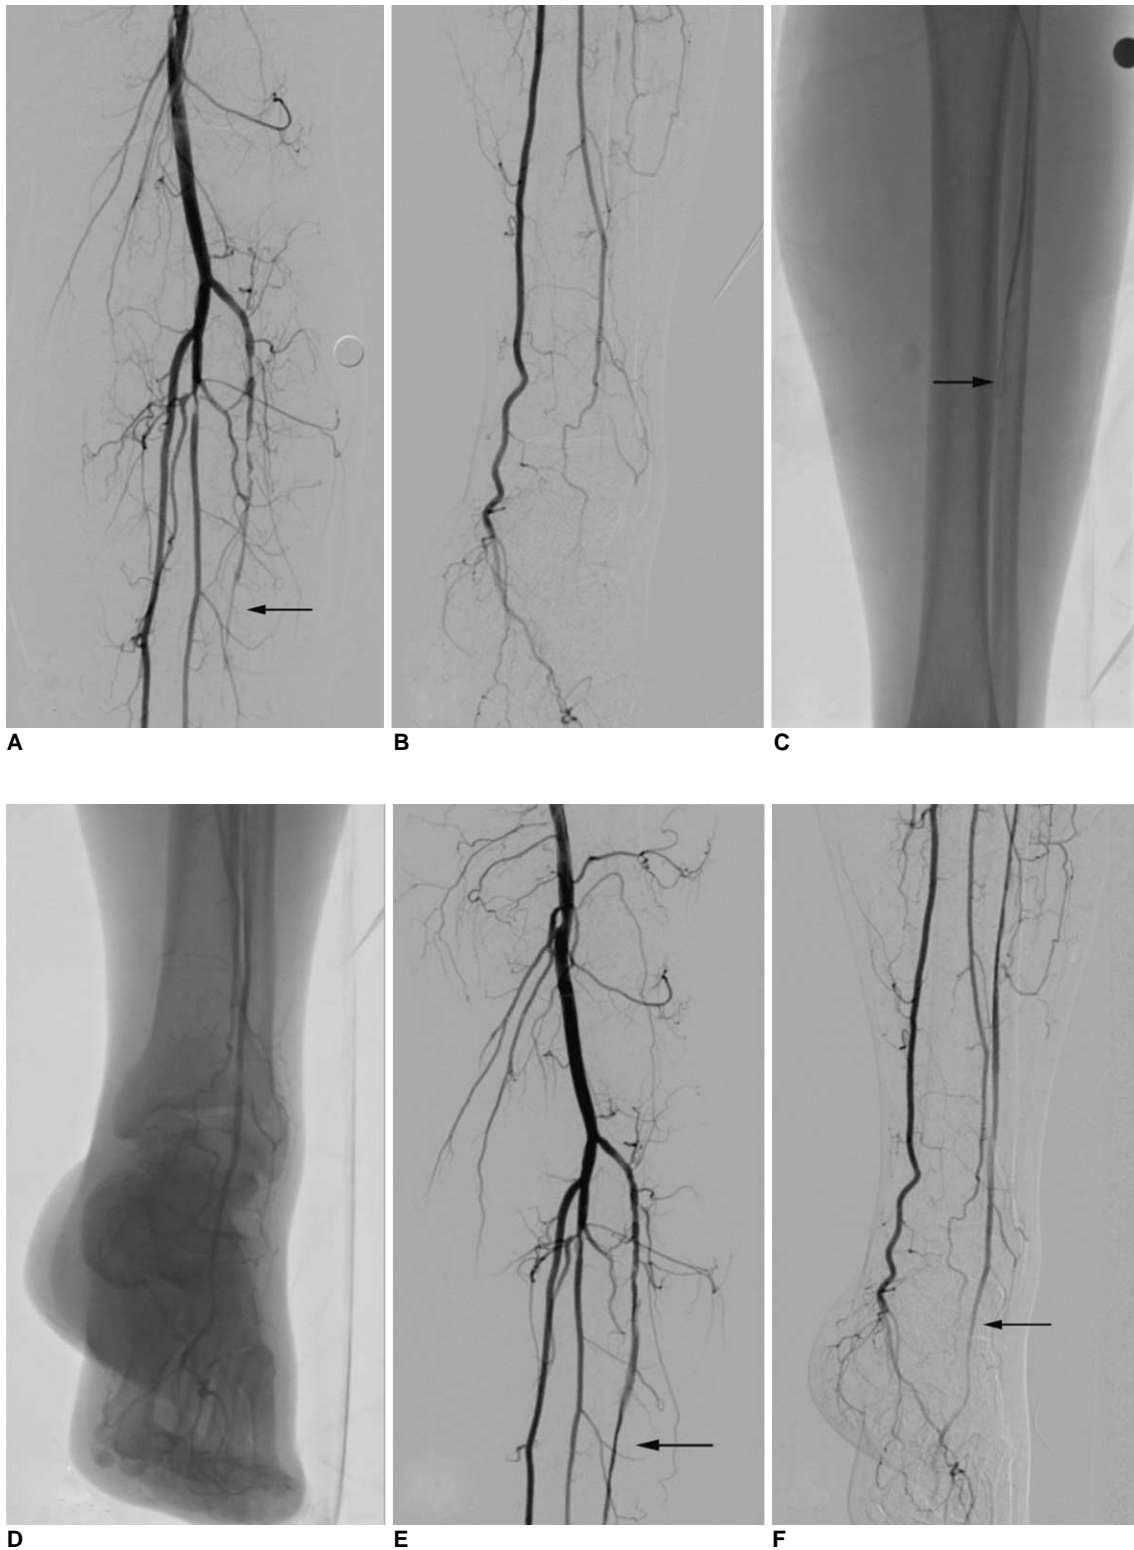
67-year-old man with more than 10-year history of diabetes mellitus presented with symptoms of limb ischemia. A, B. Lateral lower limb angiogram revealed long segment of occlusive disease in anterior tibial artery along more than 15 cm, with faint run-off tract (arrow). C. Plain film showed head of hydrophilic guidewire (arrow) forming loop when passing through occlusive segment through 4-Fr vertebral catheter. D. Fluoroscopic angiogram demonstrated run-off tract indicating true lumen process. E, F. Immediate angiogram performed post-procedure showed restoration of anterior tibial artery with straight-line flow to pedal arch. Residual stenosis was less than 30% (arrows).
